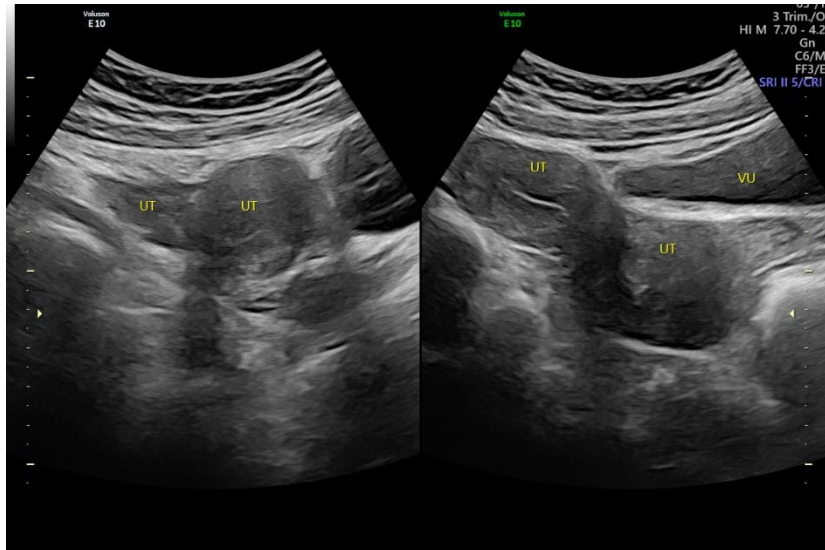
Pelvic ultrasonography post operative revealed not found hematocolpos and there is uterine didelphys
